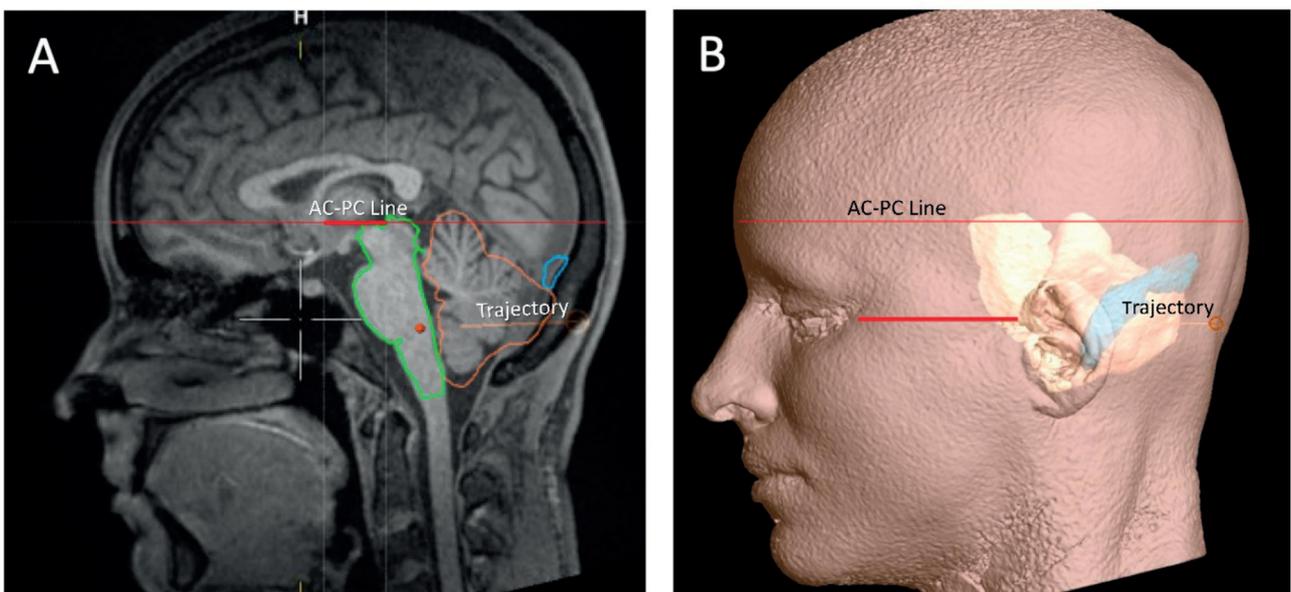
Target, entry point, and trajectory in relation to important anatomical structures like brain stem (light green), cerebellum (orange) and sinus (blue). AC-PC overlaid on A) sagittal MRI and B) 3D image. In this case the trajectory is angled similar to the AC-PC plane
